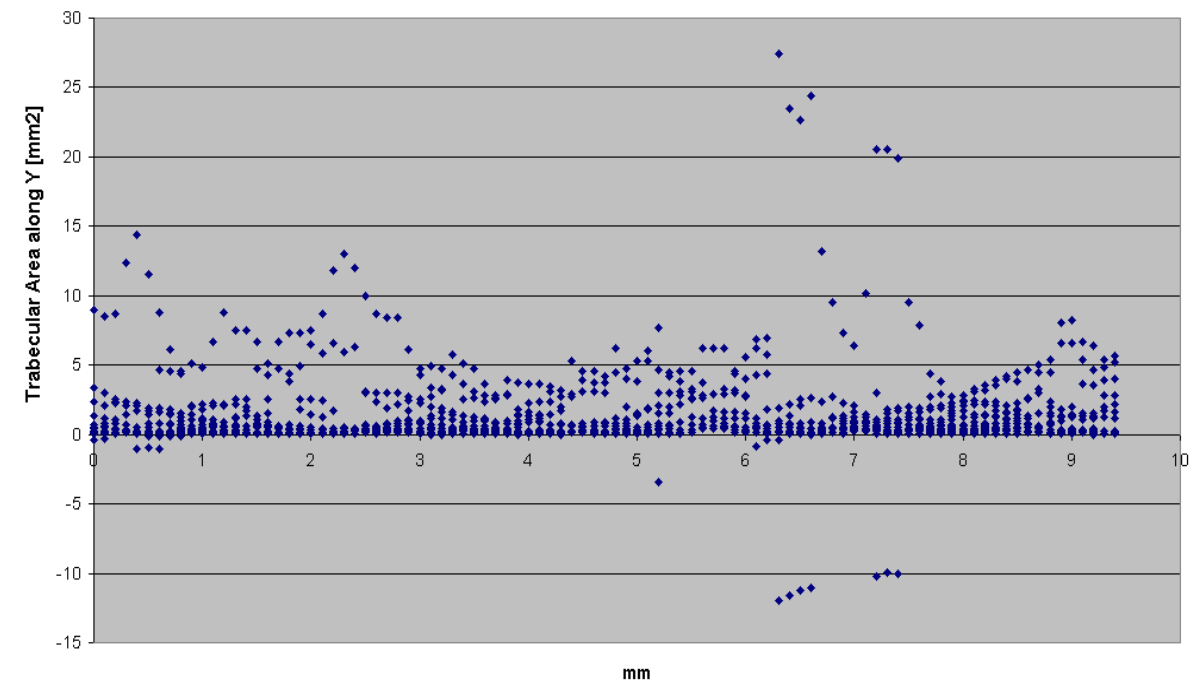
Cubic  $\mu$ CT sample: trabecular area distribution along  $Y$
